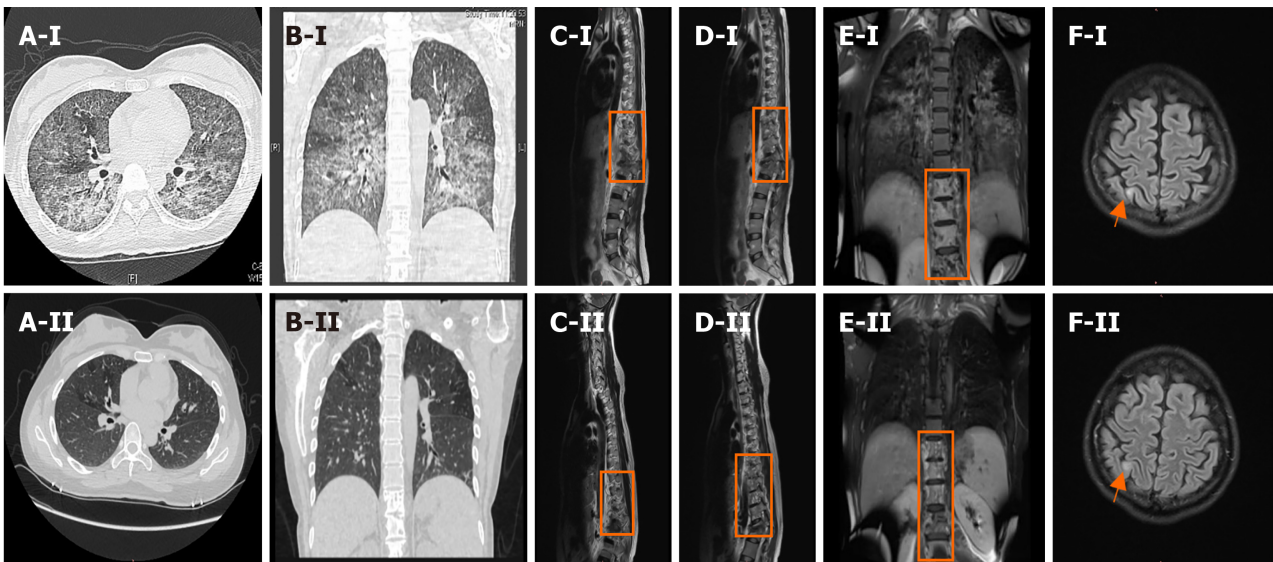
Chest computed tomography and enhanced magnetic resonance imaging of the thoracolumbar spine and brain. A-I and B-I: Chest computed tomography scans showing diffuse lesions in both lungs on admission; C-I, D-I, and E-I: Enhanced magnetic resonance imaging (MRI) of the thoracolumbar spine performed on day 13, showing abnormal signal shadows from the ninth thoracic vertebral body to the first lumbar vertebral body and the surrounding soft tissues; F-I: Enhanced MRI of the brain performed on day 12, showing an abnormal right parietal lobe signal. A-II and B-II: The chest computed tomography scan performed 6 ½ months after admission, showing an improvement in the diffuse lesions in both lungs. C-II, D-II, and E-II: Enhanced MRI of the thoracic spine performed 6 ½ months after admission, showing improved signal shadows from the ninth thoracic vertebral body to the first lumbar vertebral body and the surrounding soft tissues; F-II: Enhanced MRI of the brain performed 6 ½ months after admission, showing similar signal intensities in the right parietal lobe and the frontal lobe.
